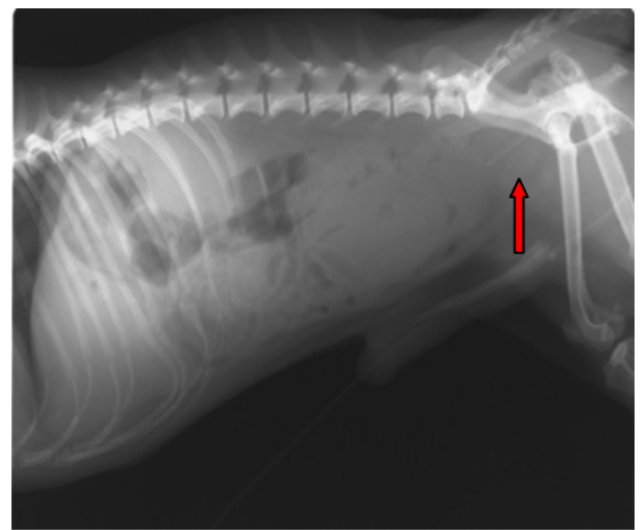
Radiography revealed enlarged prostate with uniform radio density of the gland after catheterization and evacuation of urine
